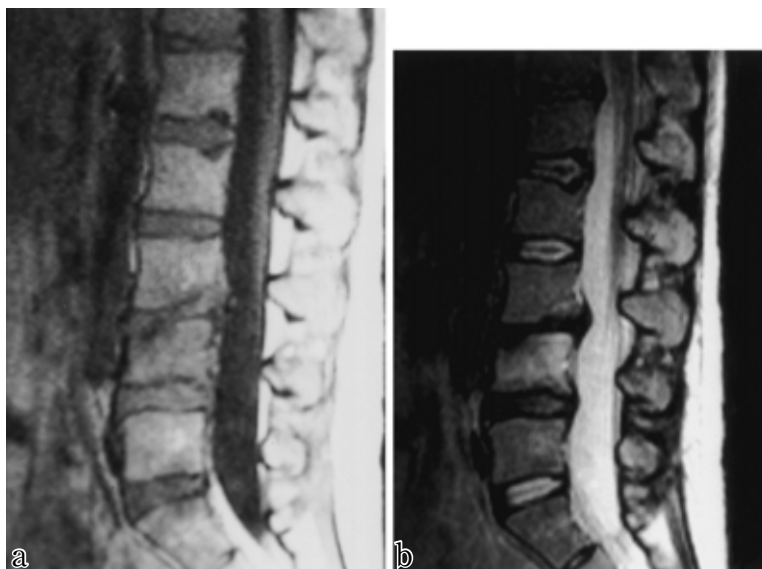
MRI at admission to our hospital (September 1998). MRI shows low signal intensity on T1 weighted image and high signal intensity on T2* weighted image in the entire L4 body, suggesting inflammatory lesions. Fig. 5-a: T1-weighted image, Fig. 5-b: T2*-weighted image
